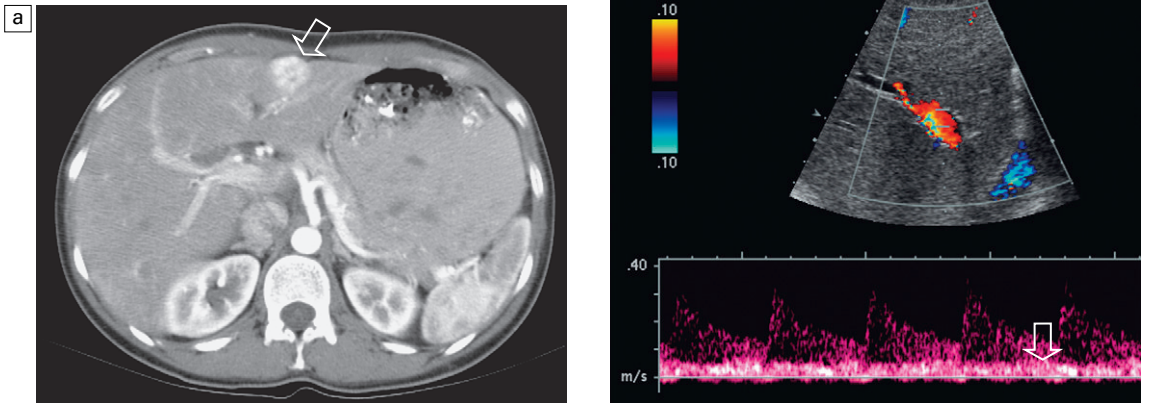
(a) Contrast enhanced CT scan in a patient with a biopsy proven hepatocellular carcinoma. A brightly enhancing lesion on the early arterial phase is identified in segment 2 (left lobe lateral segment) (arrow). (b) Spectral Doppler tracing of the left hepatic artery and portal vein show changes characteristic of liver disease and neoplasm. Note the relatively high arterial diastolic flow and low resistance. Note, however, the attenuated portal vein inflow (arrow).
